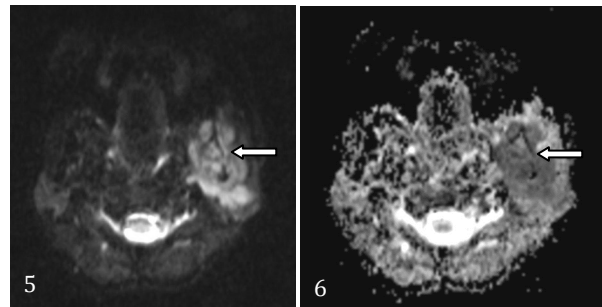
DWI & ADC: Showing restricted diffusion of the mandibular lesion.
